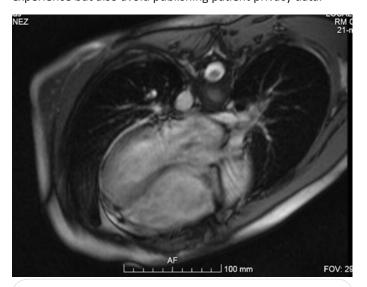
Cardiac Magnetic resonance imaging. Dilated right cavities.
